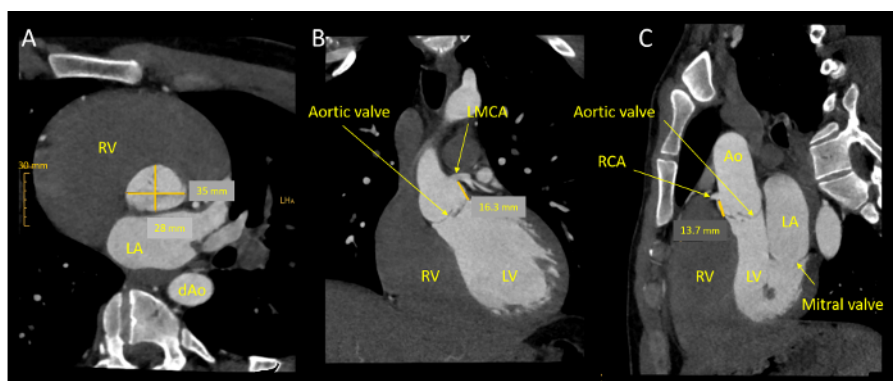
CT measurements for pre-operative planning from the same patient as in Figure 1. (A) Annulus sizing. The largest and shortest aortic annulus are both greater than the 20 mm criterion for selection of the patients given in Table 1. (B) Distance from the left coronary ostium to the aortic annulus. This distance is greater than 12 mm criterion for selection of the patients given in Table 1. (C) Distance from the right coronary ostium to the aortic annulus. This distance is greater than 12 mm criterion for selection of the patients given in Table 1 (1 mm in scale = 2.9 mm). CT measurements of this patient fulfills the CT criteria for selection of the patients for right anterior mini-thoracotomy with pleural entry in the second ICS. RV = right ventricle, LA = left atrium, dAo = descending Aorta, LMCA = left main coronary artery, LV = left ventricle, RCA = right coronary artery, Ao = ascending aorta. [Please click here to view a larger version of this figure.](#)
